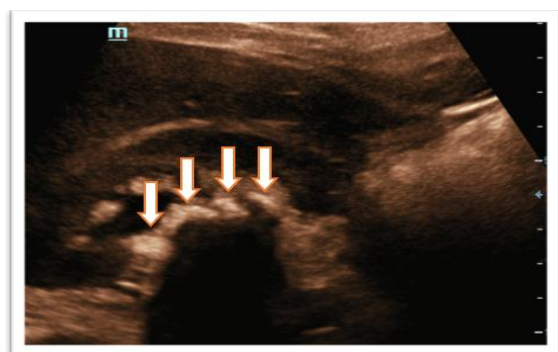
Multiple left renal calculi with caliectasis seen on gray scale ultrasound.
